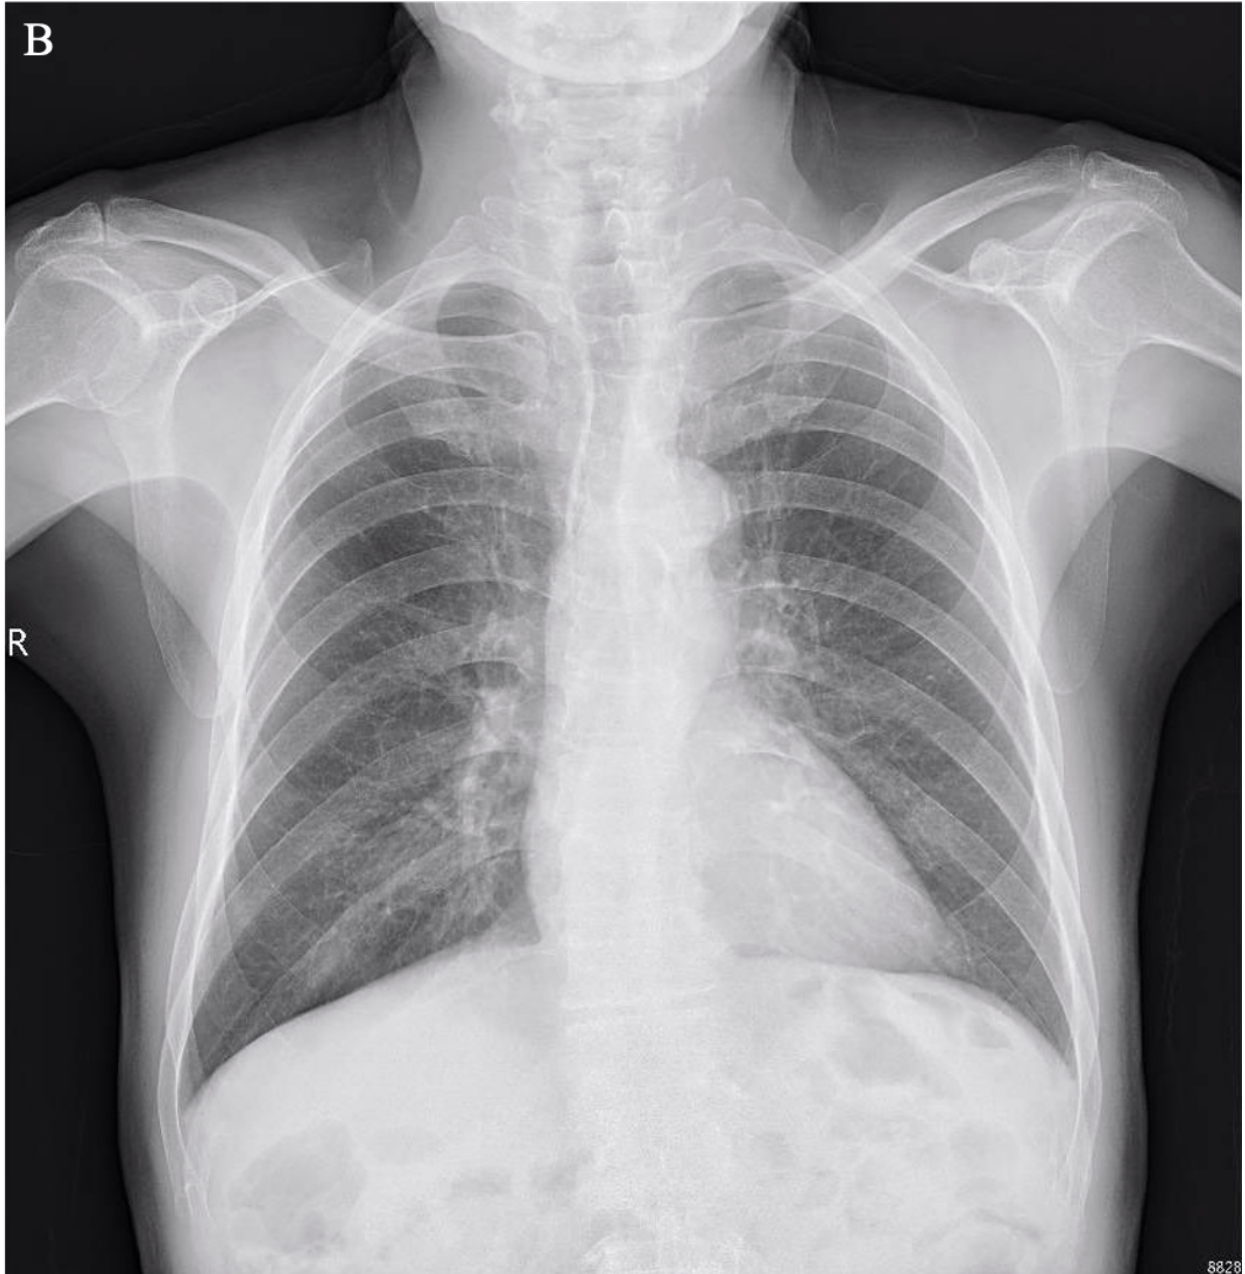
Chest X-ray examination of patient 1. The Chest X-ray of patient 1 showed no remarkable changes before (A) and twelve months (B) after the injection.
